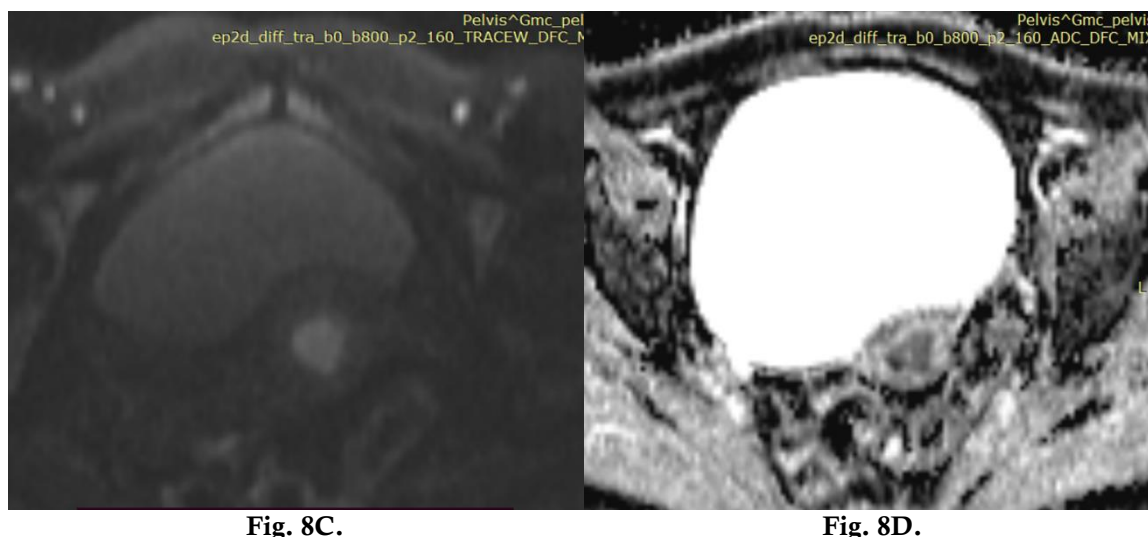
Sagittal T2WI (8A) shows a hyperintense area in the endometrial canal showing heterogenous enhancement on post contrast scan (8B). The mass depicts restricted diffusion on DWI (8C) with corresponding low signal on ADC map (8D) - Biopsy was positive for Endometrial Adenocarcinoma.
